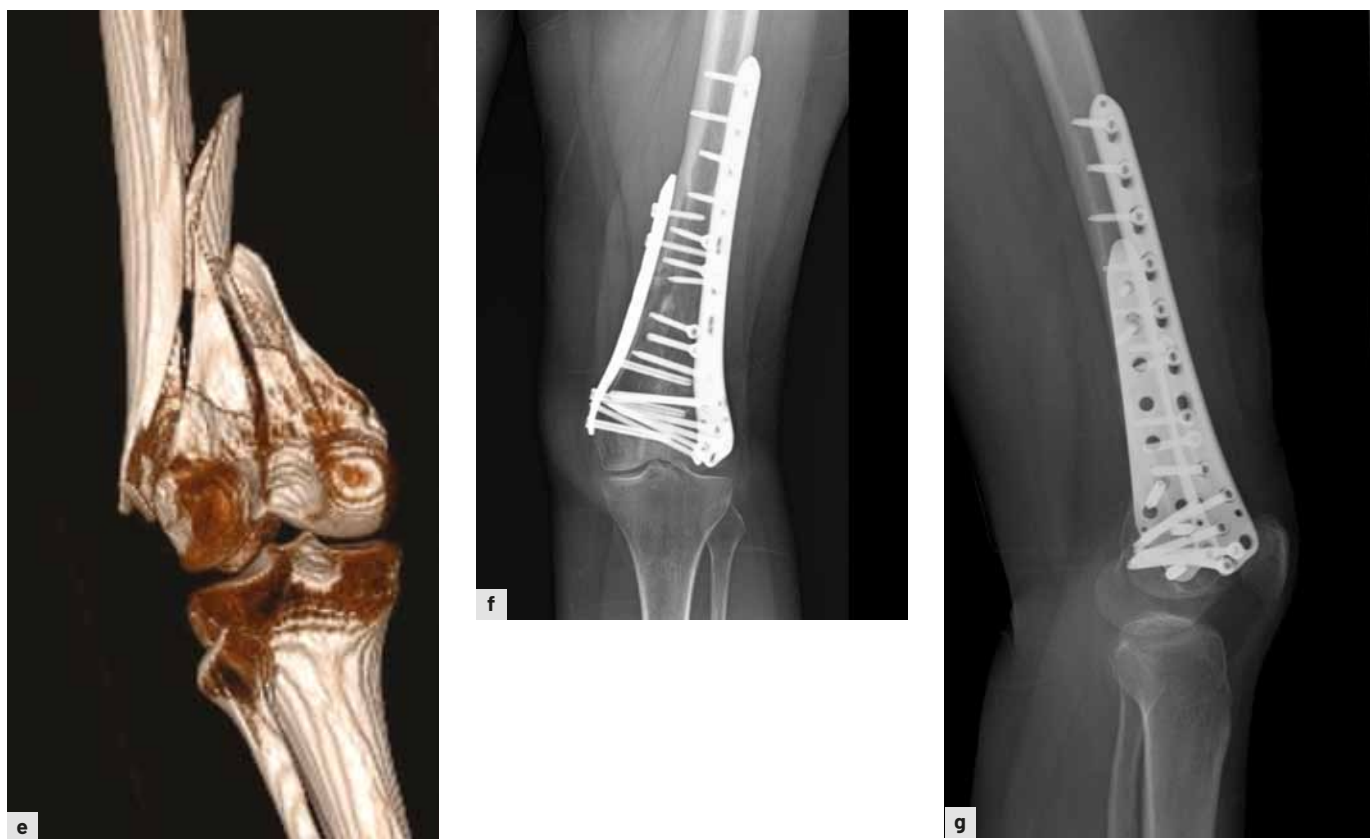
a – preoperative radiographs demonstrating an OTA/AO type 33-C2.3 distal femoral fracture with medial comminution and lateral displacement tendency. b, c, d, e – preoperative computed tomography (CT) images revealing simple articular involvement with a comminuted metaphyseal component. f, g – postoperative radiographs at 5 months showing evidence of fracture union with bridging callus formation medially, laterally, and posteriorly.
